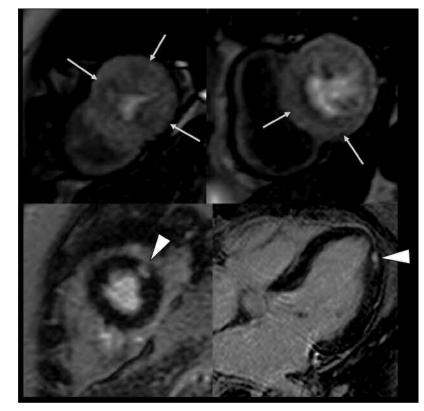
This case shows nonsegmental perfusion defect with segmental delayed enhancement. A. Stress perfusion MRI shows nonsegmental perfusion defect (arrows). B. Delayed enhanced imaging shows small focal enhancement (arrowheads) in intermediate layer.
